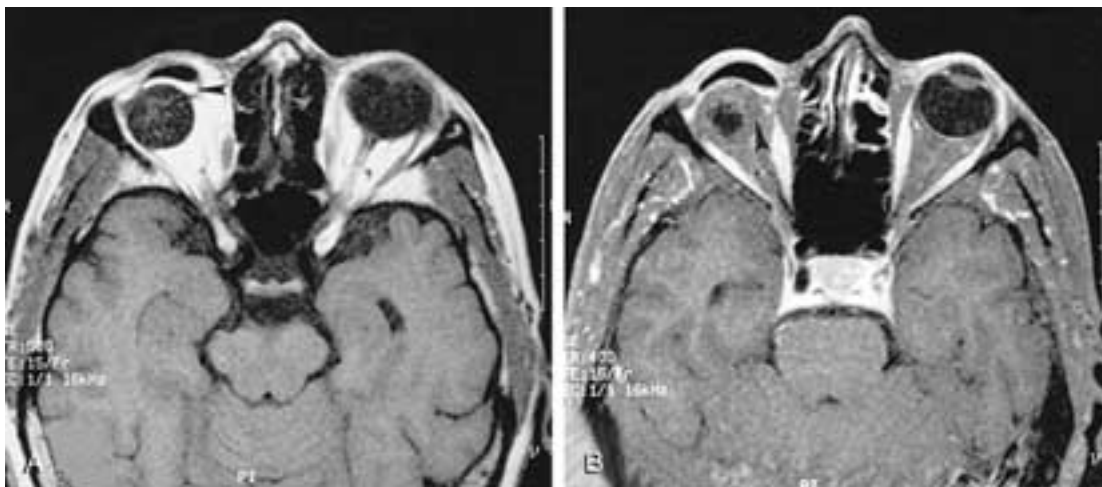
Enucleation with a porous polyethylene implant and an overlying dermis fat graft. A, Axial T1-weighted MR image shows the hyperintense signal of the dermis fat graft (arrowhead) anterior to the orbital implant and posterior to the ocular prosthesis. B, Axial T1-weighted, gadolinium-enhanced, fat-suppressed MR image shows the hyperintense signal of the rectus muscles consistent with a favorable blood supply. The hyperintense signal of the periphery of the orbital implant is consistent with early vascularization of the porous implant (arrowhead).
